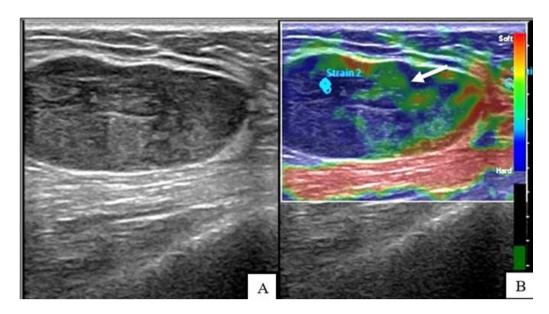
(A) Ultrasonography of a palpable breast lesion showing a well-defined, hypoechoic solid lesion with posterior acoustic enhancement, suggestive of BIRADS 3 lesion. (B) On elastography, the lesion demonstrated mosaic patterns of blue and green (thick white arrow) suggestive of equivocal lesion.
